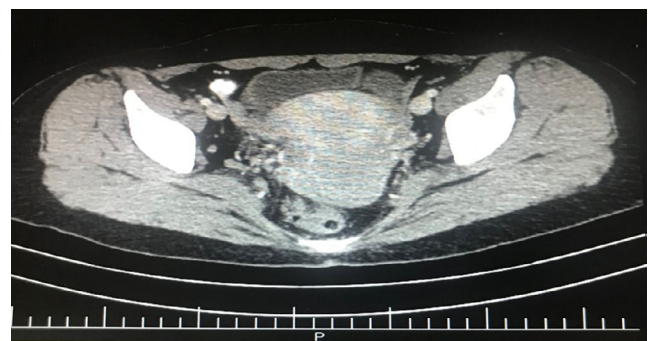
Axial section of CT scan showing the increase in size of the cervix with no cervical mass
